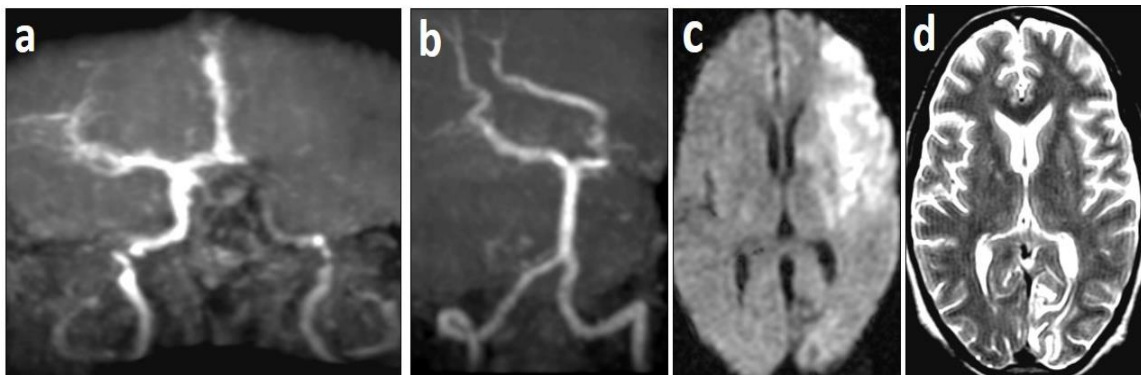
(a-d); (a&b) 3D TOF MRA show occluded Lt. ICA with no flow through Lt. MCA, a plaque at Rt. ICA and a stenotic segment at Lt. PCA. (c) DWI b1000 shows a bright signal in the distribution of left MCA. (d) T2WI shows no abnormal signal in the same area with a bright signal encephalomalacic area at the left occipital region.
